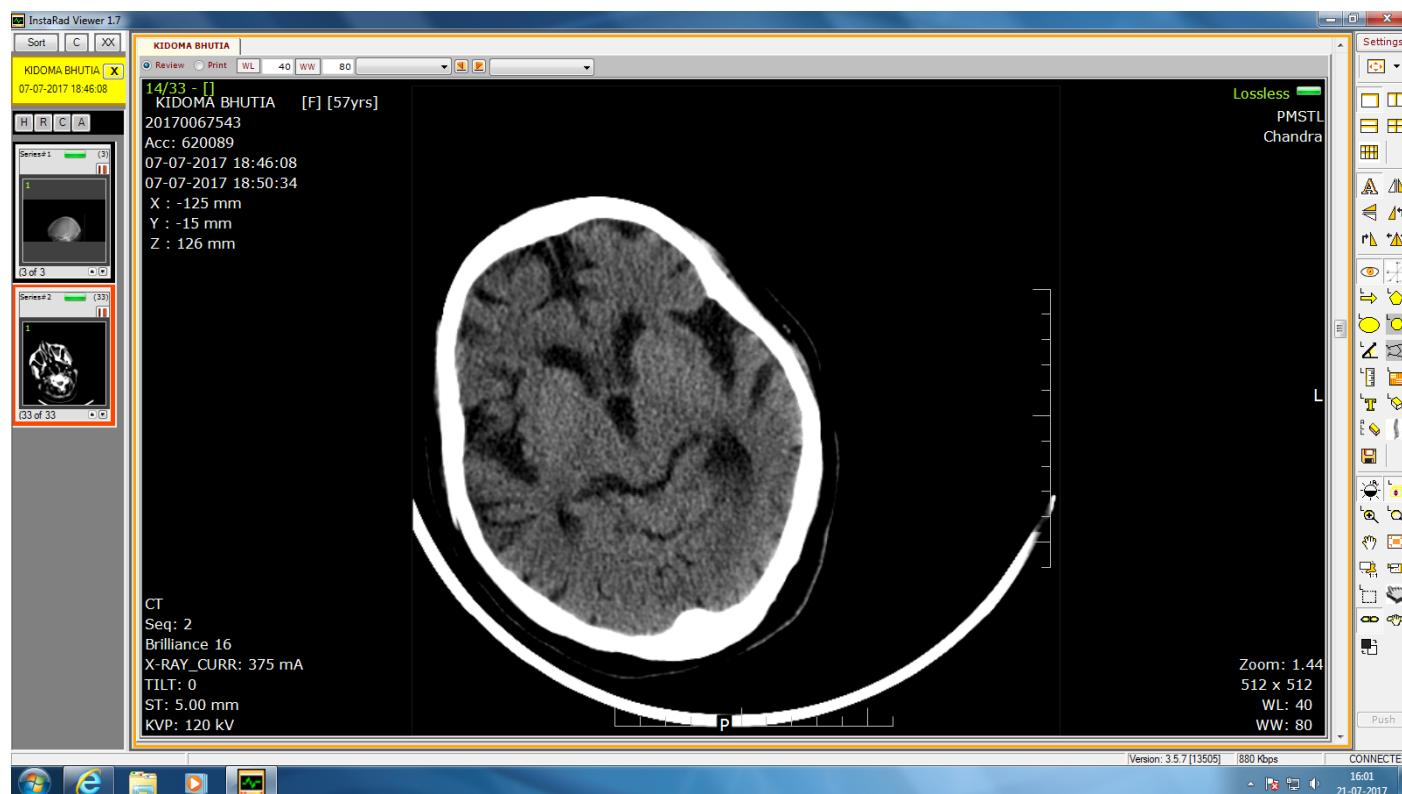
CT scan at our center which also showed asymmetrical dilatation of ventricle, left more than right with significant atrophy on the left temporo parietal region
